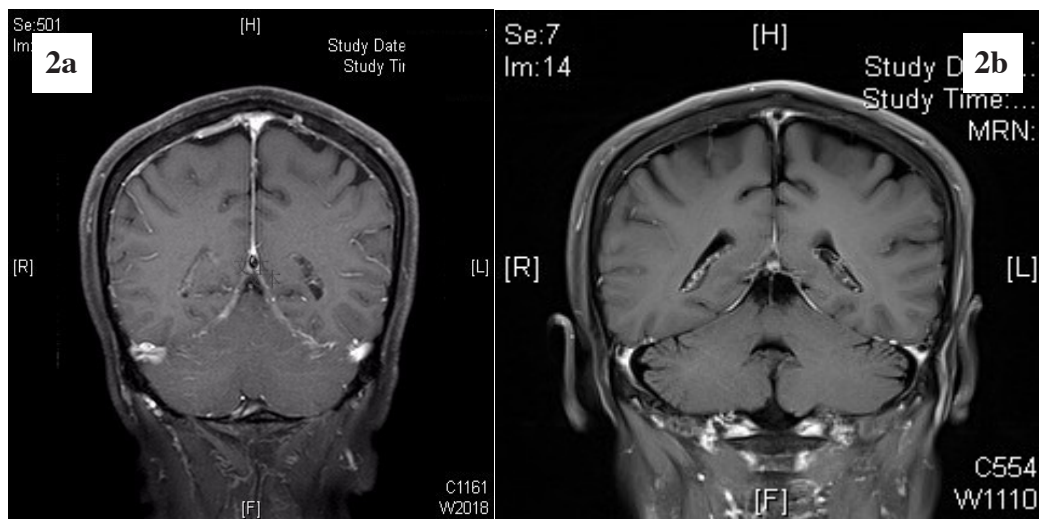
Linear enhancement of the dura mater on coronary enhanced T1-weighted MR imaging (2a), and the diminishment of this change in the follow-up study (2b).
